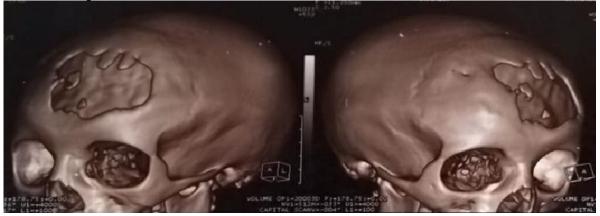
3D CT of skull bone show rarefaction and thinning of bone table.
